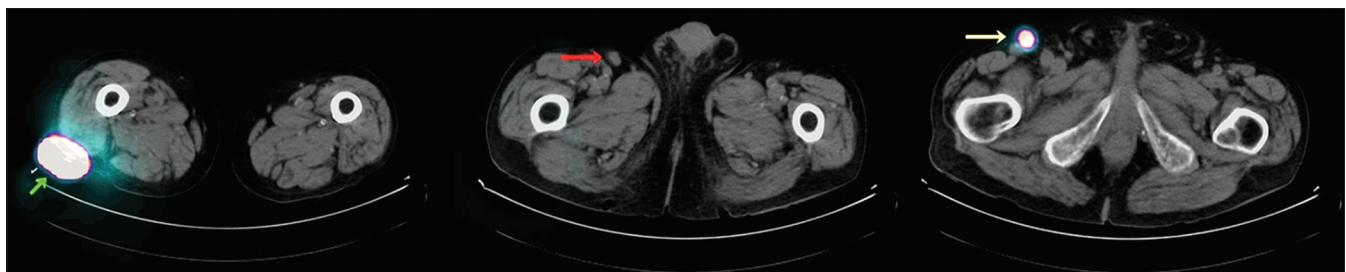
Axial views of single-photon emission computed tomography/computed tomography (CT) lymphoscintigraphy with ^{99m}Tc-nanocolloids. Tracer uptake can be seen in the site of injection/primary tumor (green arrow) and in a right inguinal node (yellow arrow), while there is no uptake in a crural node with suspicious aspect on CT images (red arrow)
